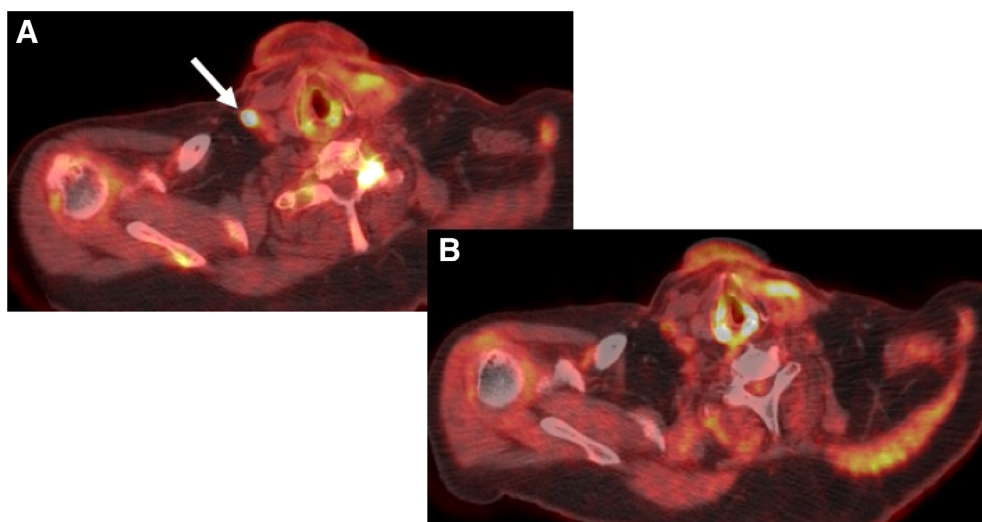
Radiological course of lesion in the second case in axial view. Axial fused positron emission tomography/computed tomography image at baseline (A) shows a fluorodeoxyglucose-avid focus in the right neck (arrow), which has resolved on follow-up (B).
